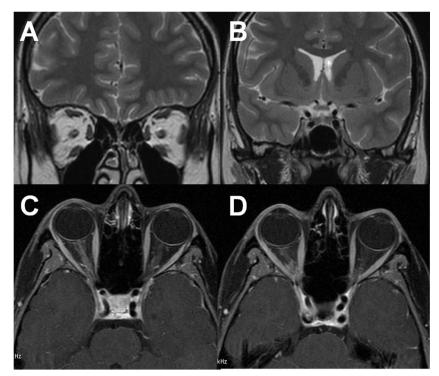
Coronal high resolution T2-weighted MRI (A, B) and axial T1-weighted MRI (C, D) show the resolution of inflammation and the absence of abscess.
